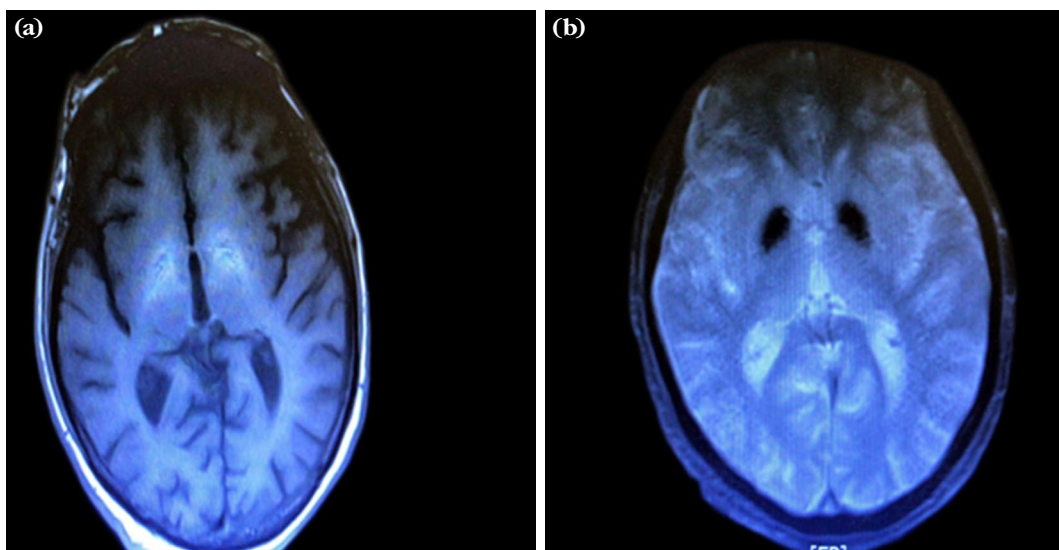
(a) Increased signal in bilateral globus pallidus was detected in T1-weighted sections. (b) Decreased signal on gradient echo sequence.
